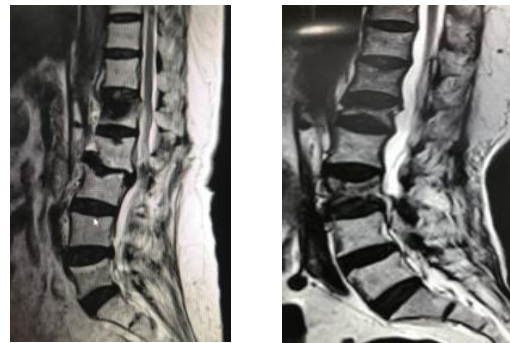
MRI T2WI L-S spine sagittal views of OVF showing more than 50% canal encroachment.
